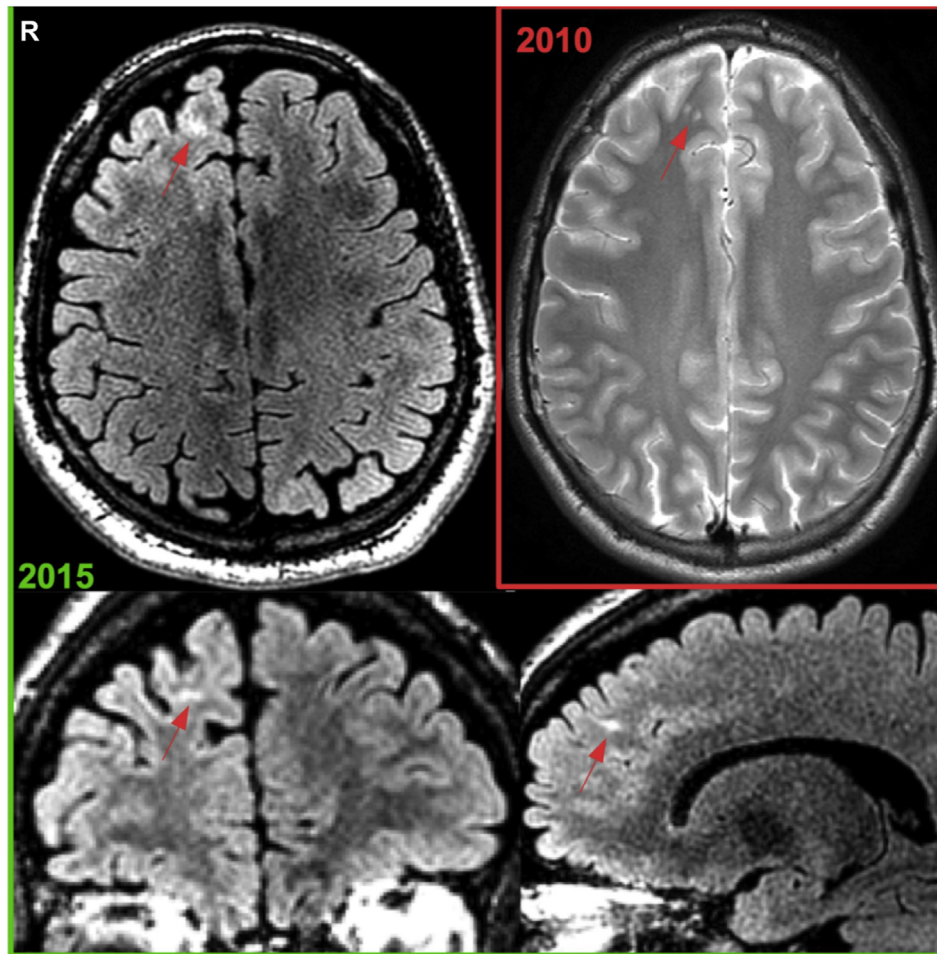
Patient 65: FCD / gliosis in right superior frontal gyrus. Diagnosis was made based on the 3D T2-FLAIR image of 2015 (green image borders). The abnormality was not reported on the previous 2D axial T2-w image (red image borders) where only one slice showed the small abnormality. R = right.
